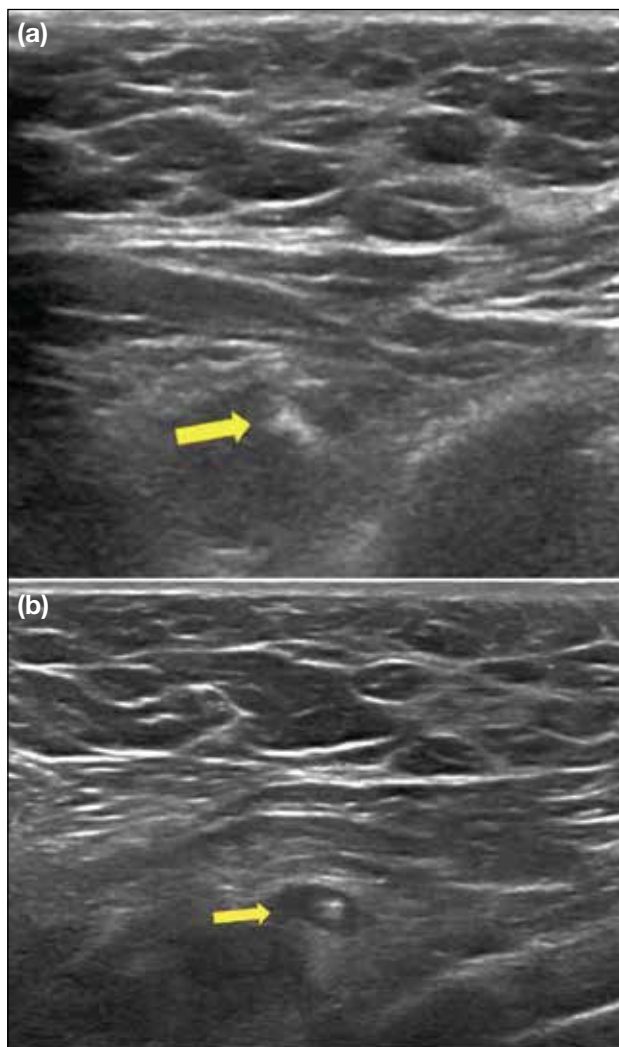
A 44-year-old woman had biopsy-confirmed left axillary nodal metastasis from an ipsilateral intraductal carcinoma (not shown). (a) A hydrogel-based marker was placed in the node and was seen as a small echogenic structure on ultrasound at the time of deployment (arrow). (b) Ultrasound 1 week later demonstrated the marker being more clearly visualised as a nearly anechoic oval structure of the hydrated hydrogel embedding the echogenic marker (arrow).
